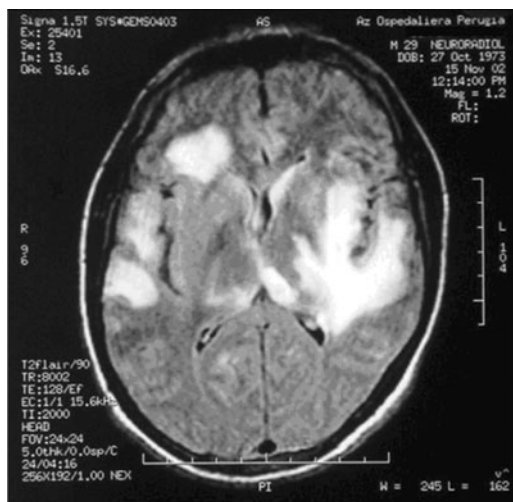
Brain imaging of the patient (MRI, T2-weighted FLAIR), 8 days after admission, showing multiple focal areas of increased signal with hemorrhagic component within the lesions.
